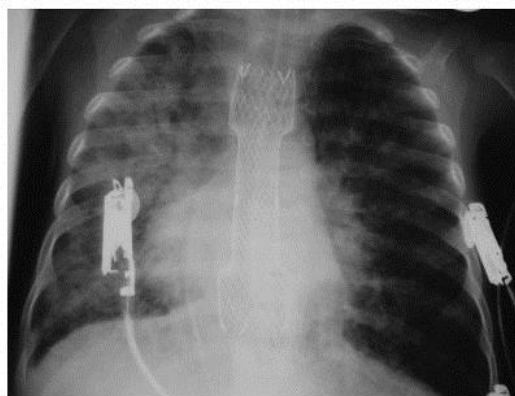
Post-esophageal stent insertion. The radiograph demonstrates the stent, an endotracheal tube, a naso-gastric tube, and a central venous line inferiorly. There is persistent extensive air-space disease in the right lung and less marked lingular and left lower lobe disease.
